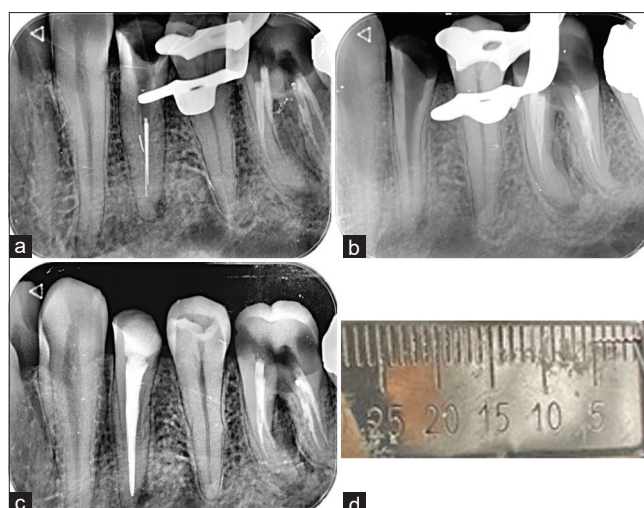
Case 1 with three separated instruments in tooth #21. a) Radiographic examination showing three separated instruments in the canal. b) The instruments were retrieved from the canal and confirmed with a radiograph. c) Root canal treatment completed. d) The length of one of the separated instruments.
